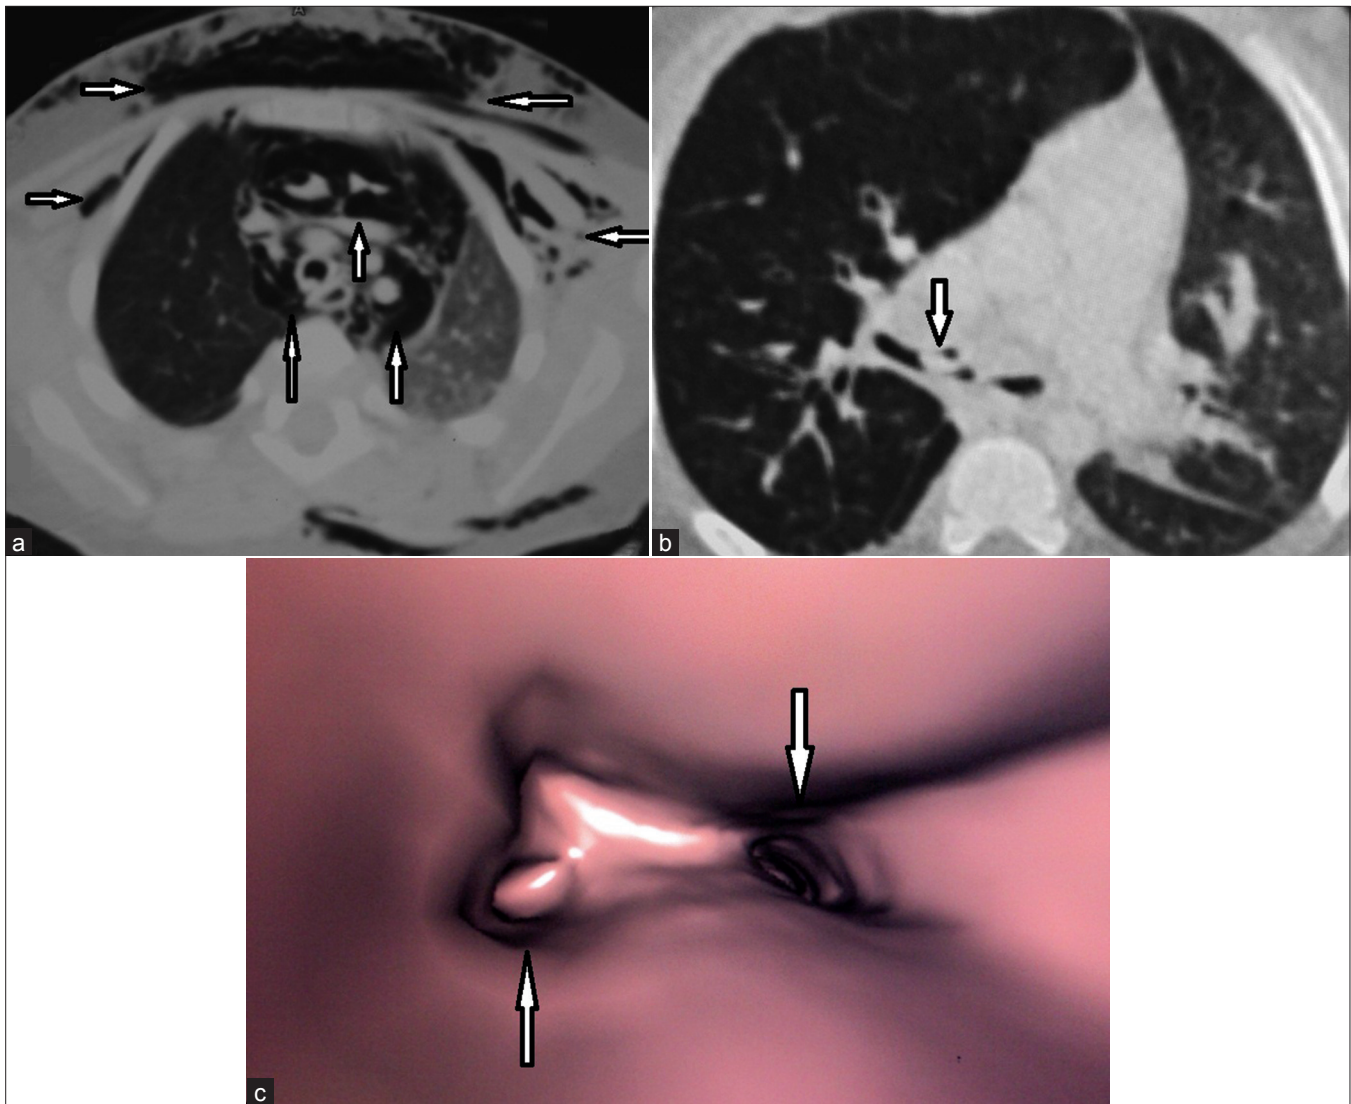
(a) Transverse lung window CT image through the upper lobes showing mediastinal gas (upward arrows) and gas in the chest wall (right and leftward arrows) on both sides (pneumomediastinum with subcutaneous emphysema). (b) Transverse lung window CT image through main bronchi shows soft tissue attenuation structure within the lumen of right main bronchus (arrow); right lung appears more lucent as compared to left due to hyperinflation. (c) Virtual bronchoscopy image through the carina shows an occluding lesion within right main bronchus compatible with a foreign body (upward arrow); left main bronchus is patent (downward arrow).
